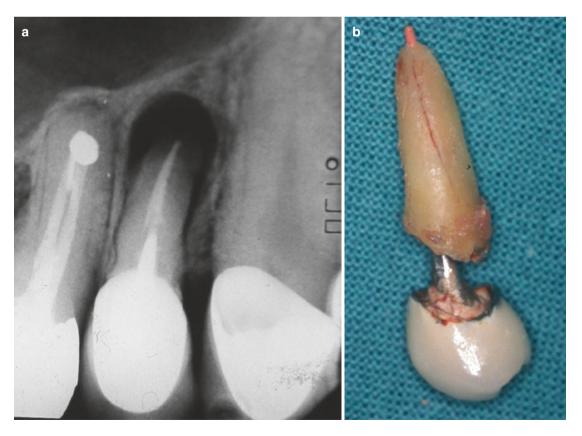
Vertical root fracture associated with a massive post cemented. (a) A dental radiography of the crowned upper premolar with a massive post cemented with periapical radiolucency. (b) The same tooth was removed showing vertical fracture, a massive post as well as protruding
